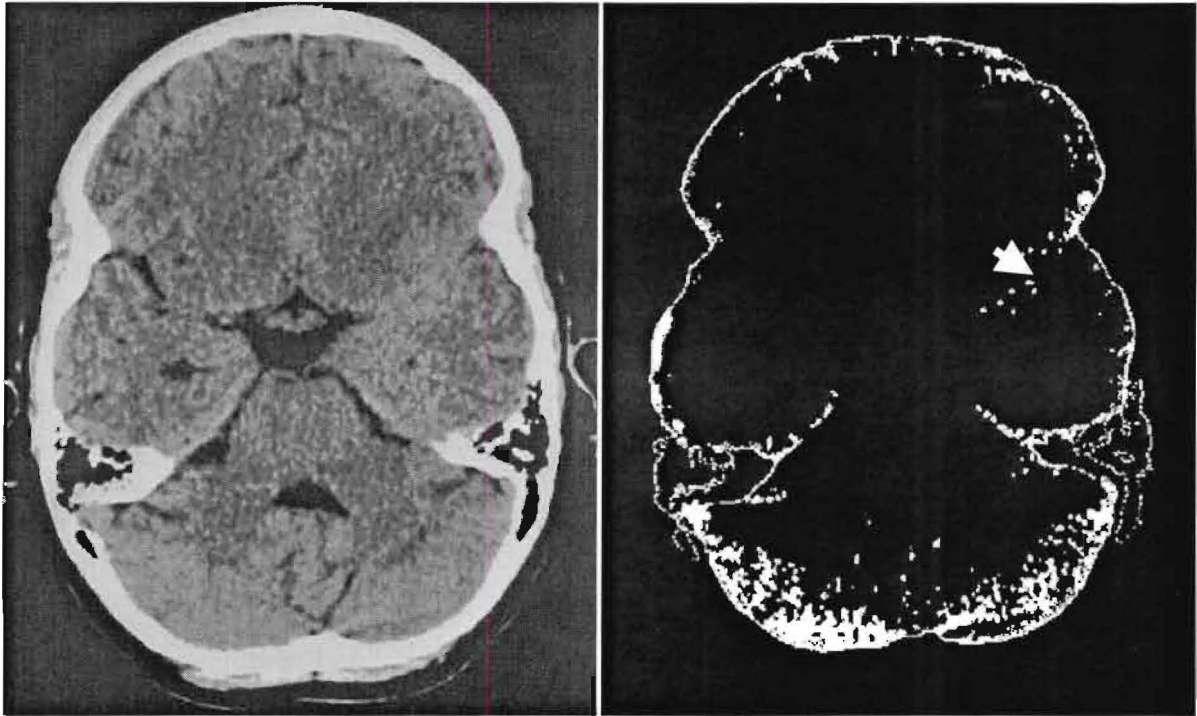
Showing the original CT image on the left and the hyperdense cluster on the right after being clustered twice with UOFC.
